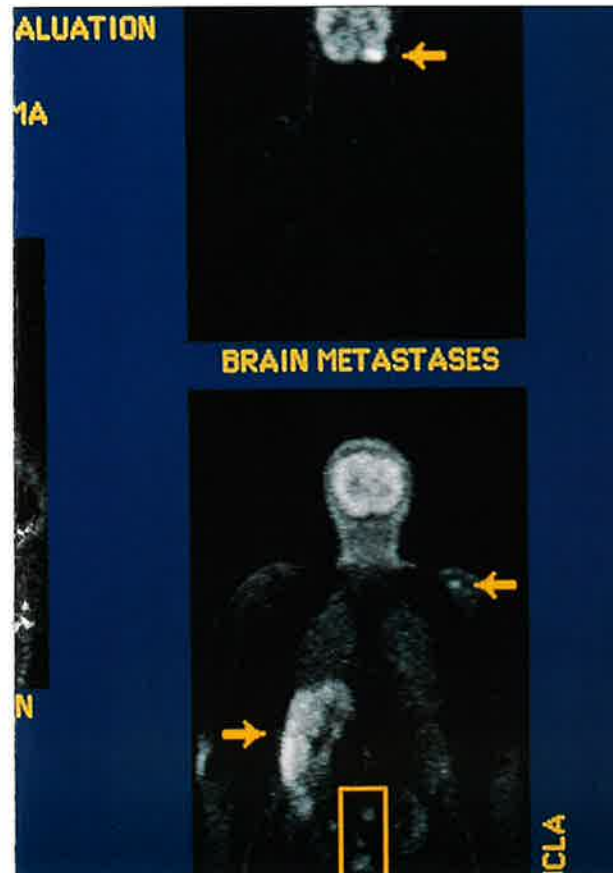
Whole-body PET scans with glucose analog FDG. In the center is a primary breast cancer; the other images show metastatic disease elsewhere in the body.
